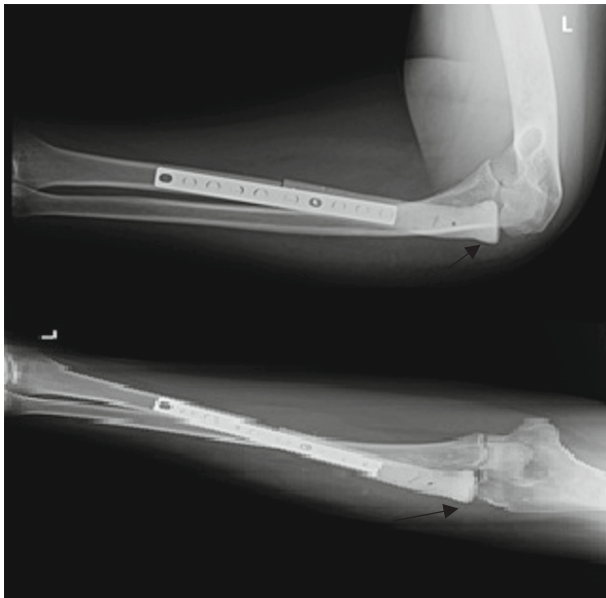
Anterior-posterior and lateral radiographs of the left forearm 3 months after the surgery showing stable construct and no change in shape of radial head with a congruent joint (arrow).
